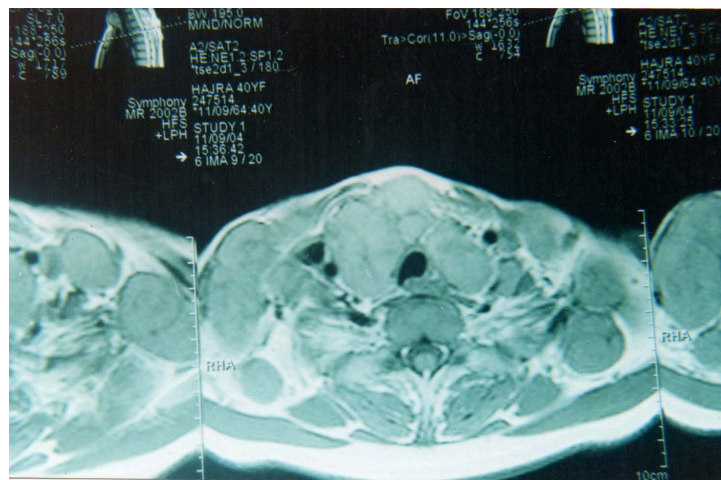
Axial MRI scan of neck showing capsular disruption of thyroid gland by papillary carcinoma, and multiple-level cervical nodal involvement.
